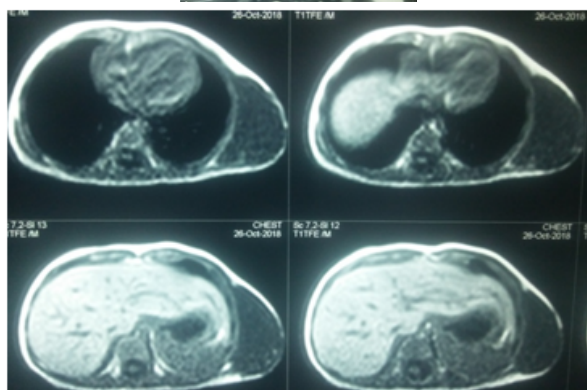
MRI showing a well defined cystic lesion with septations in the subcutaneous plane with intermuscular extensions favouring a lymphangioma
